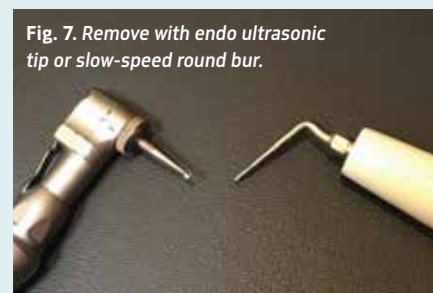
Remove with endo ultrasonic tip or slow-speed round bur.
